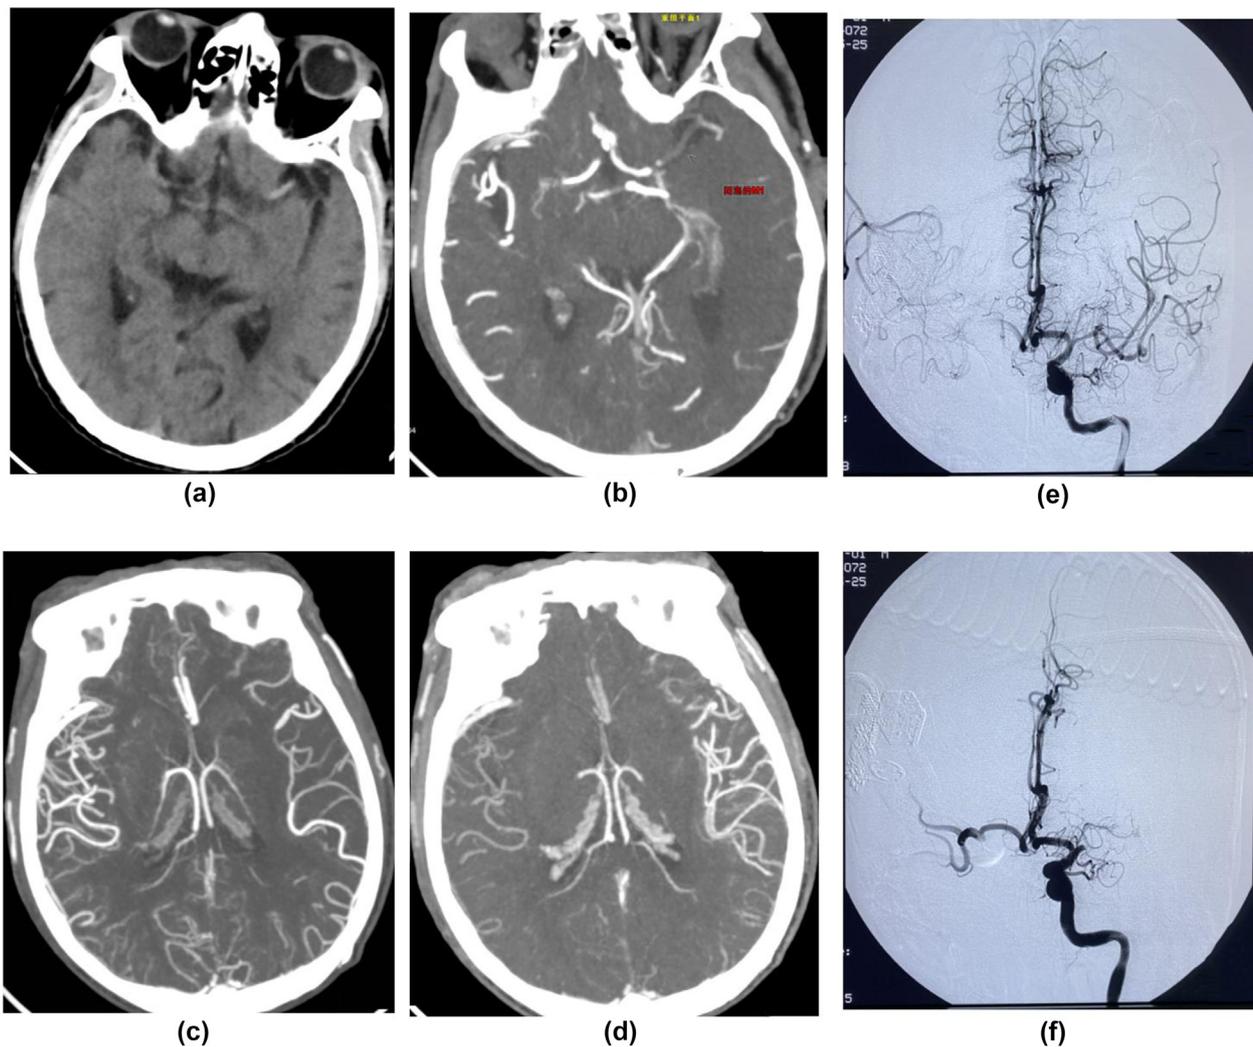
The patient was a 73-year-old male with speech impairment and right limb weakness for 5 hours. His NIHSS score was 19. A, NCCT scan showed high-density thrombosis in the left middle cerebral artery. B, CTA clearly shows the responsible vessels. C and D, Multistage CTA has good collateral compensation. The patient underwent arterial thrombectomy. E, Preoperative DSA angiography was consistent with CTA. F, Postoperative recanalization was good, TICI 3 grade. NIHSS, National Institutes of Health Stroke Scale; NCCT, Noncontrast computed tomography; CTA, computed tomography angiography; mTICI, modified Thrombolysis in Cerebral Infarction; DSA, Digital subtraction angiography.
